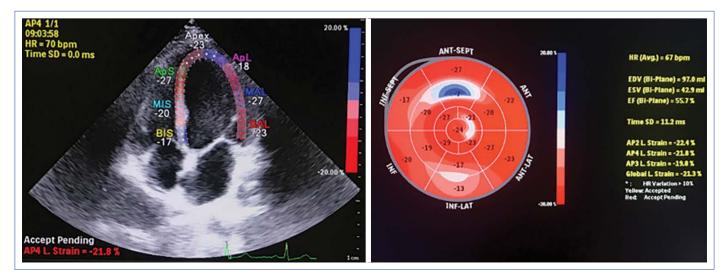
An example of the left ventricle global longitudinal strain speckle-tracking of a patient from apical four chamber views.
